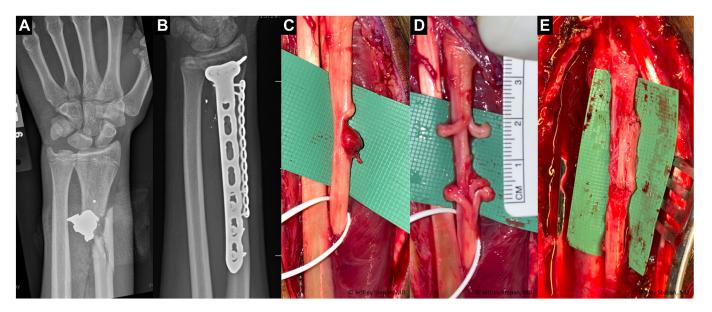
GSW injury sustained with partial median nerve deficit and radial shaft fracture. A PA wrist radiographs. B Intraoperative fluoro demonstrating fixation of the radial shaft fracture in a bridge construct. C Exploration of the median nerve at time of fracture fixation 10 days after injury demonstrating a partial nerve laceration. D Intraneural dissection and identification of healthy fascicles and injured fascicles. E Nerve grafting of the median nerve.
